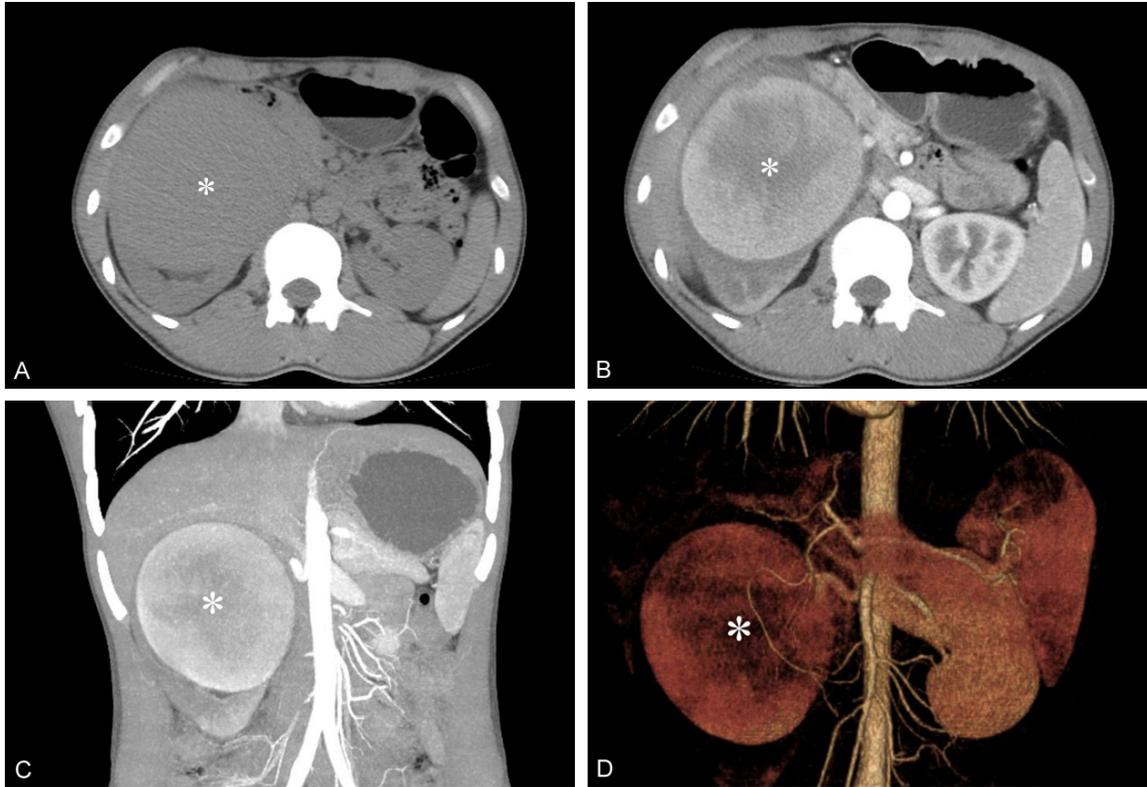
Pre-operative CTA imaging. A. Transverse imaging without contrast. B. Transverse imaging of the arterial phase. C. Sagittal imaging of the arterial phase. D. Volume rendering of the arterial phase. The RAA has been marked by “*”.
